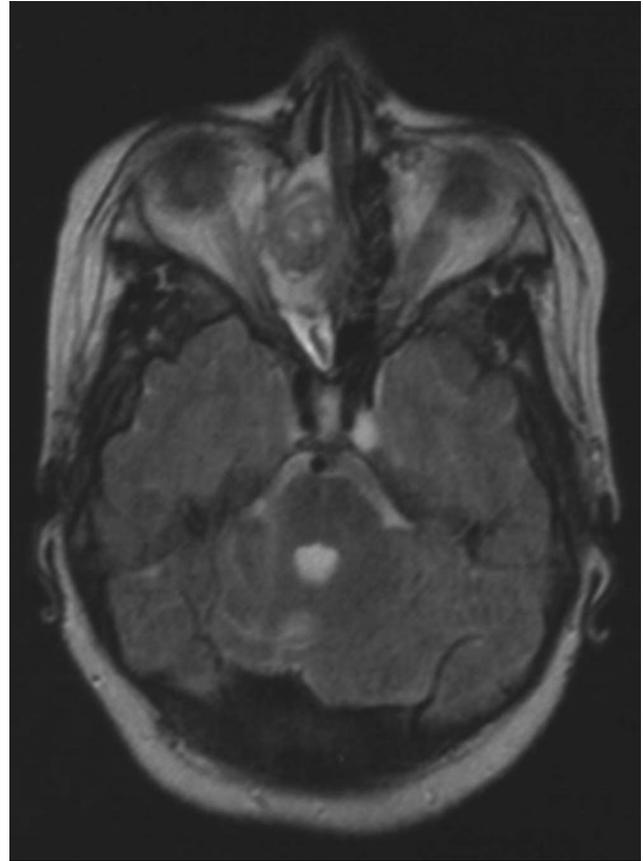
T2-weighted axial magnetic resonance image demonstrates a basal encephalocele extending into the right ethmoid sinus and the right orbit, causing diplopia and decreased ipsilateral vision.
